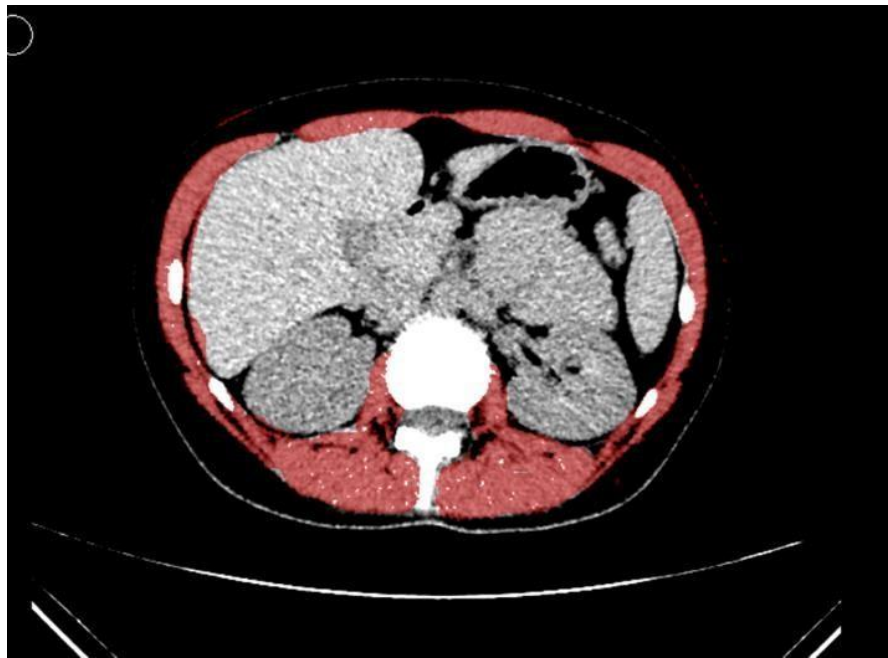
60-year-old man with sarcopenia. CT images extending inferiorly from L3 were evaluated automatically. After application of a predefined HU threshold, the boundaries were corrected manually when necessary. CT, computed tomography; HU, Hounsfield unit.
